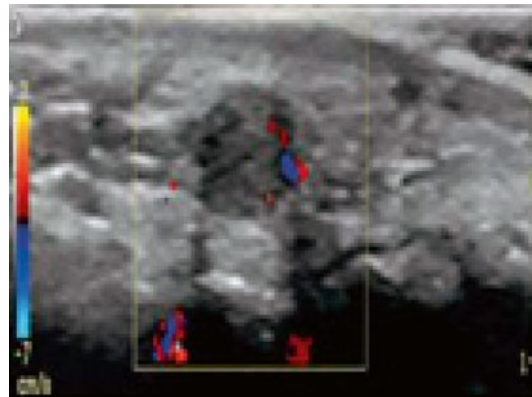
Giant cell tumor. Absence of internal vascularization on axial Doppler examination helps it to be differentiated from localized inflammation
